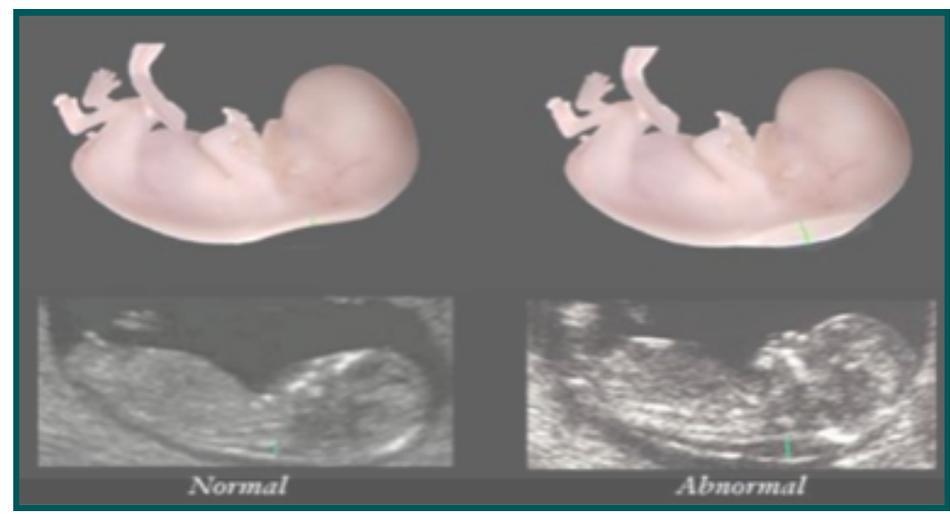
Difference between normal and abnormal foetal nuchal translucency demonstrated using ultrasonography⁵.
